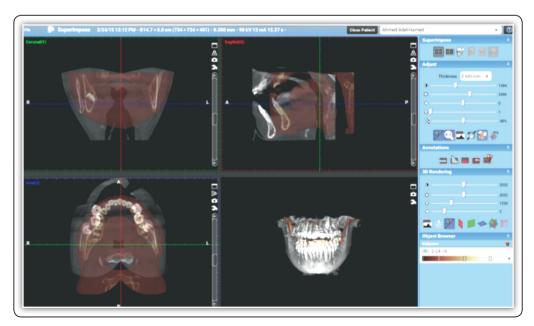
T1 and T2 CBCT images before 3D superimposition and manual refinement process.
